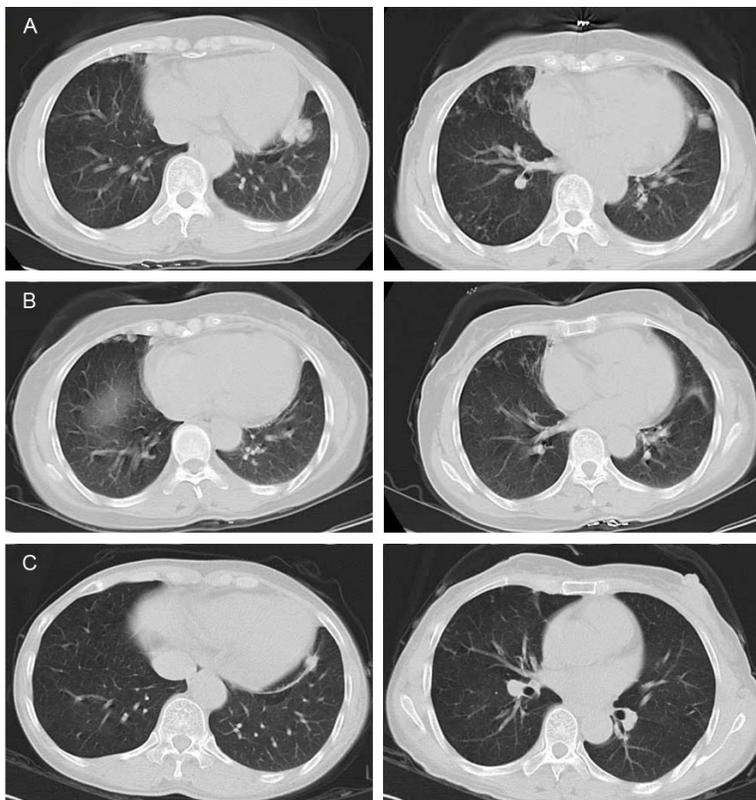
Computed tomography (CT) scans show: before crizotinib therapy (A); CT of the chest showed partial response after one months of crizotinib (B); CT of the chest revealed disease progression after thirty-four month treatment (C).
